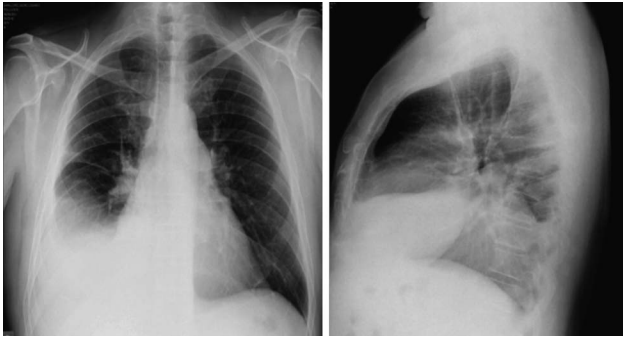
Chest x-ray posteroanterior and lateral views: right pleural effusion with atelectasis. In-circuit test limit.
